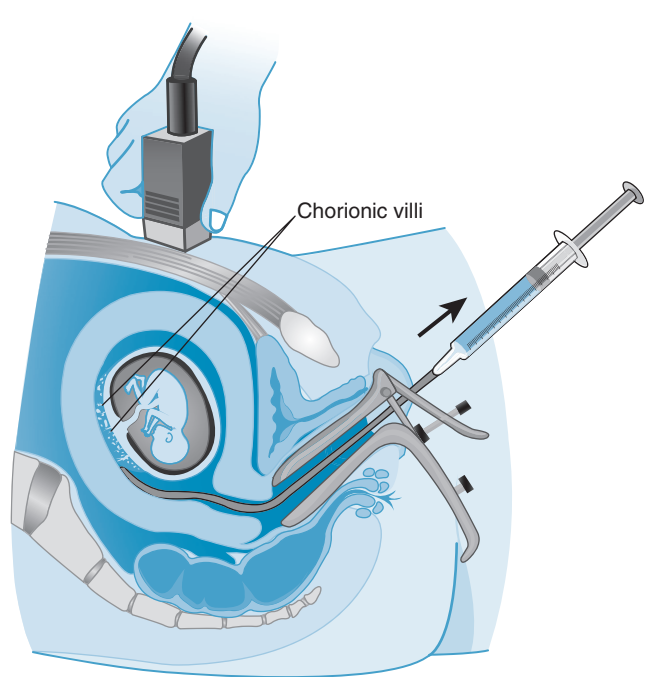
Technique for transcervical chorionic villus sampling (CVS). A very thin forceps is passed through the vagina into the placenta under ultrasound guidance. Retrieved from http://www.uptodate.com/contents/image?imageKey=PI%2F66814&topicKey=PI%2F6732&source=see_link.
